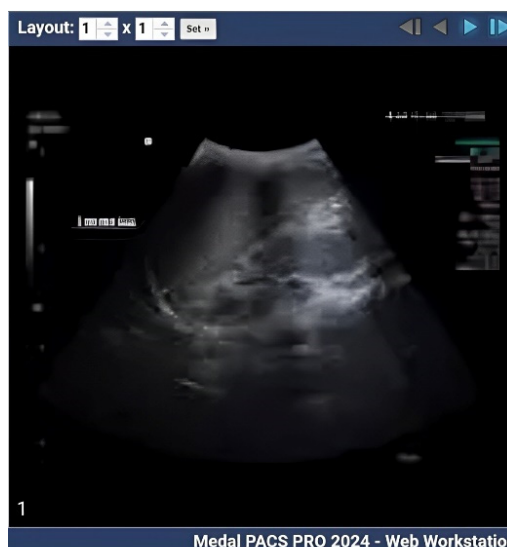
Abdominal Ultrasound- showing perforated appendix with 10 mm in diameter
